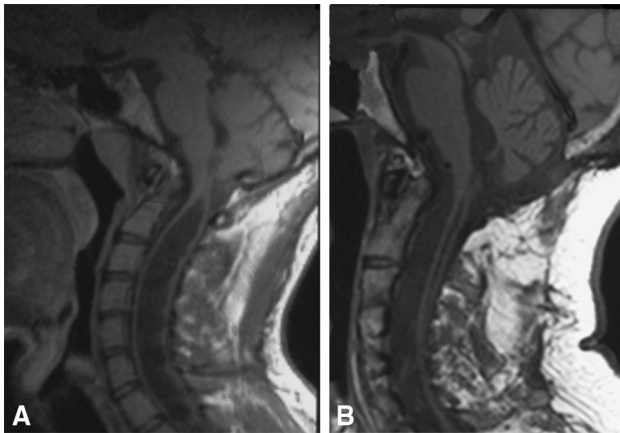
T1-weighted sagittal MR image showing syringomyelia and craniocervical malformation with basilar impression (a). MR image showing marked shrinkage of the syrinx at one year after CCD (b)
